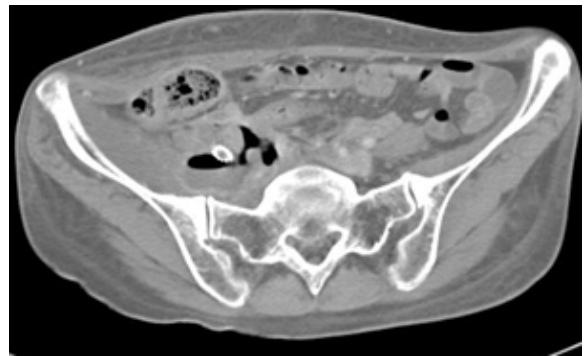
Follow up CT after 20 days demonstrates the remaining collection in the pelvic cavity and the stent placed in the right iliac artery. The lumen of the stent appear to be occluded.
